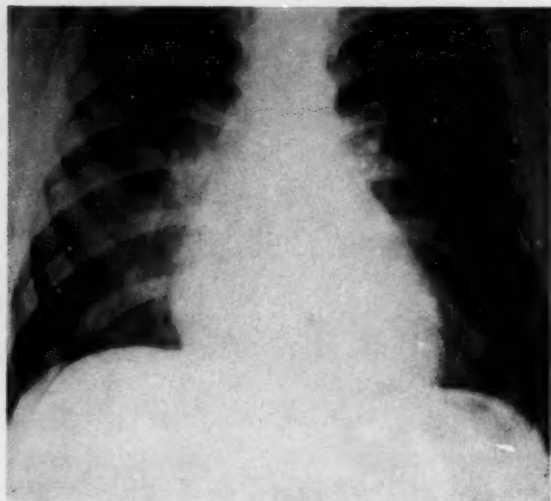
Six foot postero anterior radiograph of the chest before operation. The heart and pulmonary arteries are enlarged, and the pulmonary blood flow increased.
